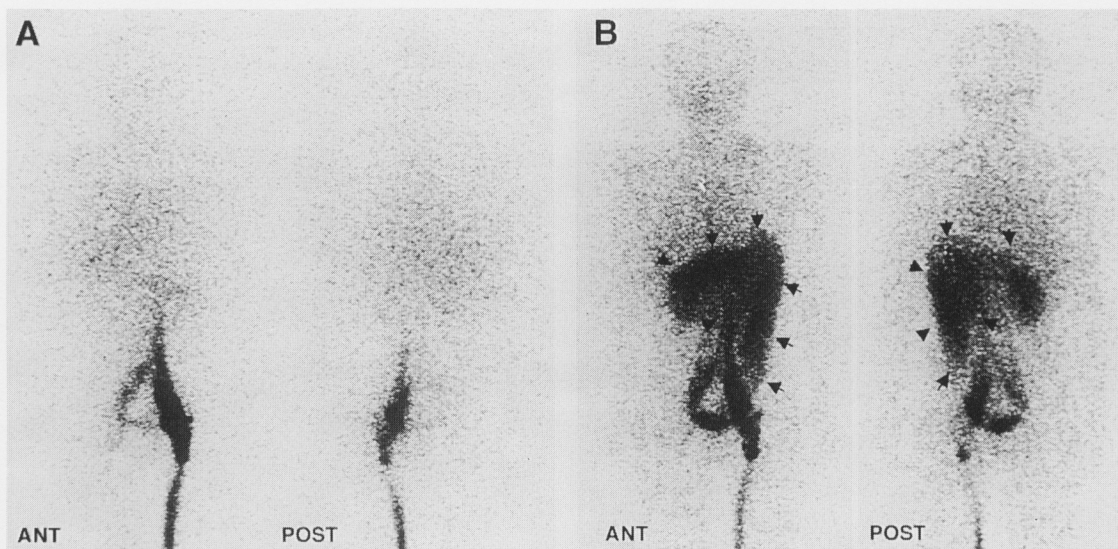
Anterior and posterior whole body images obtained 30 minutes (A) and 3 hours (B) after the subcutaneous injection of Tc-99m HSA. On the images at 30 minutes, there is no apparent abnormal activity in the region of the tumor. The abnormal activity extending from mid to left abdomen, which corresponds to the cystic tumor on CT, becomes apparent on the images at 3 hours after the injection (arrow heads).
